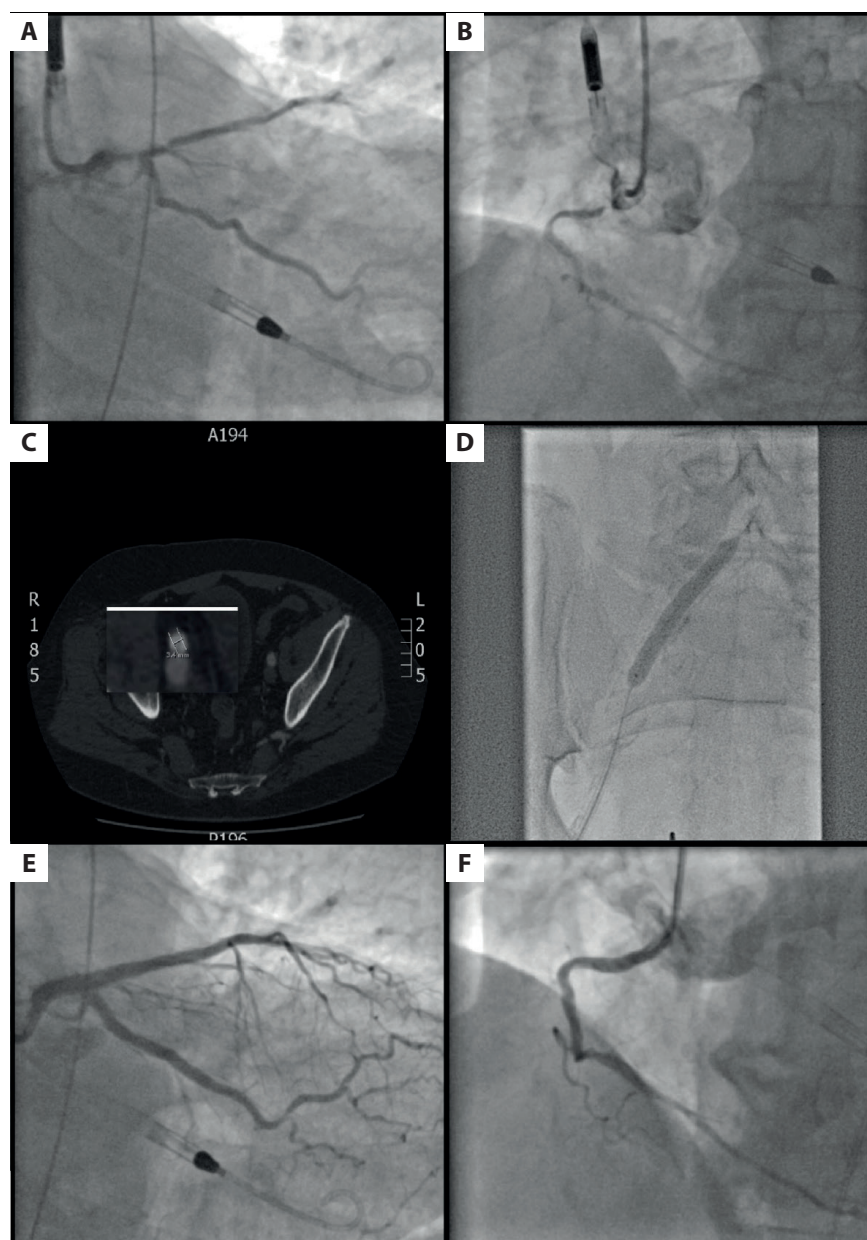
A. Coronary angiography of the left coronary artery showing severe diffuse disease. B. Coronary angiography of the right coronary artery showing a severe ostial lesion. C. Computed tomography angiography showing almost 360° calcification within the common and external iliac arteries. D. Peripheral intravascular lithotripsy with the optimal angiographic result. E. Final angiographic result in the left coronary artery. F. Final angiographic result in the right coronary artery
